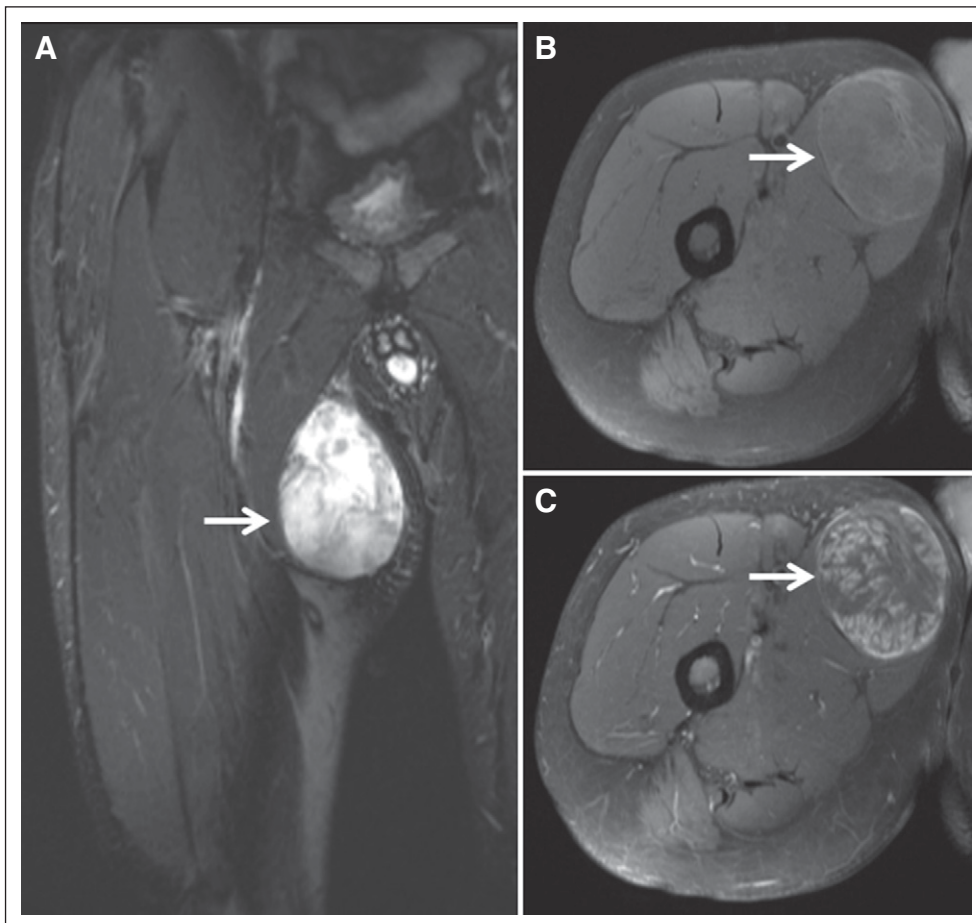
Radiologic appearance of myxoid liposarcoma of the proximal thigh. (A) Coronal T2-weighted magnetic resonance image of 80-mm tumor (arrow) with characteristic high signal intensity. T1-weighted fat-suppressed axial magnetic resonance images of (B) pre-gadolinium and (C) postgadolinium contrast show avid and heterogeneous enhancement of tumor (arrow).
